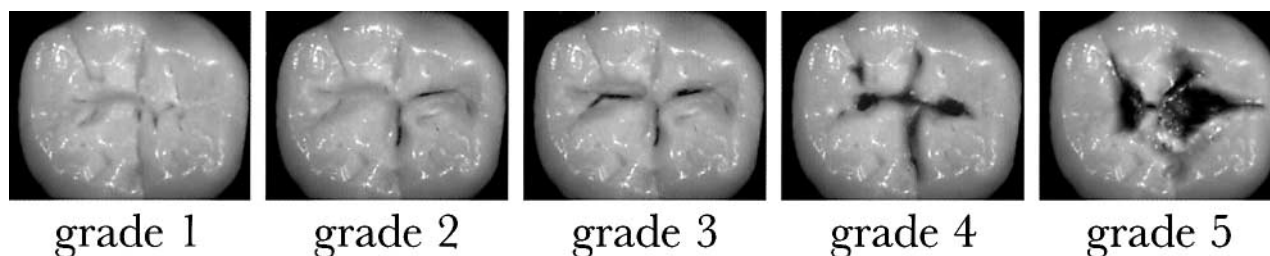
Clinical appearances of occlusal caries. The following descriptions were added beneath the grades: Grade 1. Caries characterized by white/brownish discoloration in the enamel, no cavitation. No radiographic signs of caries. Grade 2. Minor loss of tooth substance with a break in the enamel surface or discoloured surface or discoloured fissures with grey/opaque enamel and/or caries confined to the enamel. No radiographic signs of caries. Grade 3. Moderate loss of tooth substance and/or caries in the outer one-third of the dentin according to the radiograph. Grade 4. Considerable loss of tooth substance and/or caries in the middle one-third of the dentin according to the radiograph. Grade 5. Considerable loss of tooth substance and/or caries in the inner one-third of the dentin according to the radiograph.
